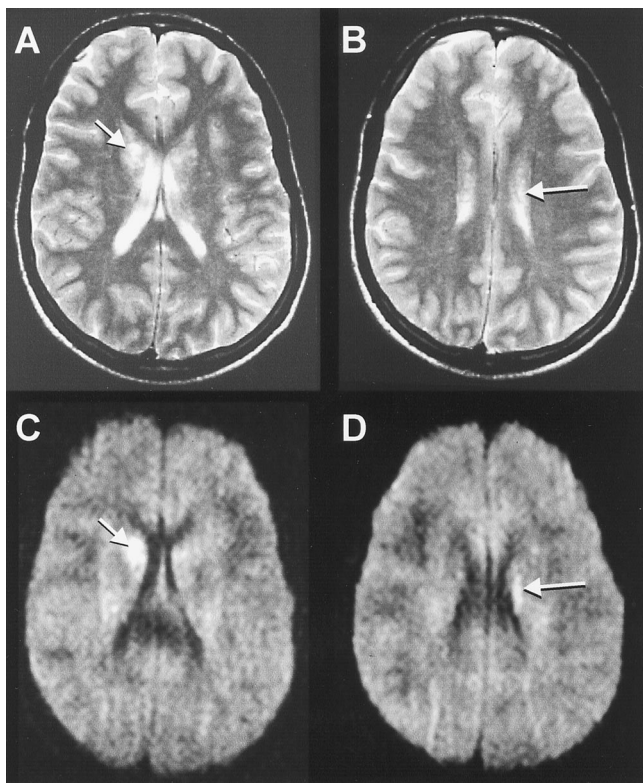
Cerebral fat embolism in a 16-yr-old male following orthopedic surgery. Initial magnetic resonance imaging (transverse scans) 10 h after surgery. Spotty areas of high signal intensity were detected in both thalami, in the head of the right caudate nucleus (arrows). (A) T2-weighted scan; (C) diffusion-weighted scan; and in the body of the left caudate nucleus (long arrows), (B) T2-weighted scan; (D) Diffusion-weighted scan.
